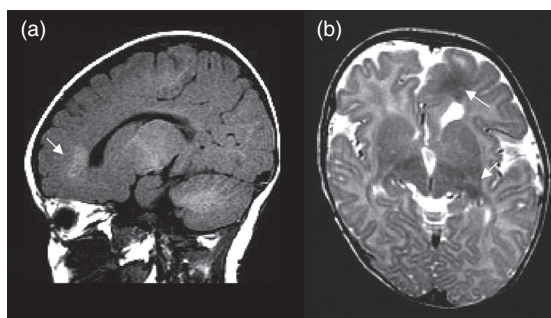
Tuberosclerosis with periventricular and subcortical tubers (arrows) on (a) neonatal sagittal T1 and (b) axial T2 MRI.
